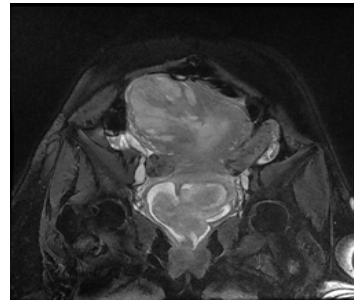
MRI: Placenta increta
